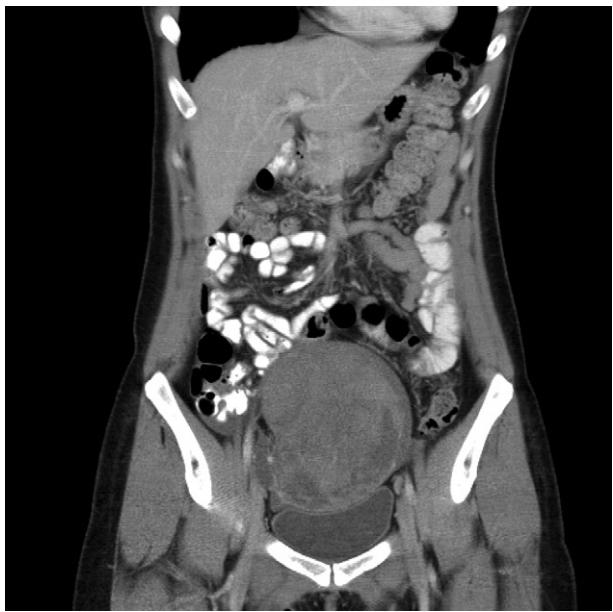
Pelvic computed tomography revealed a round-shaped heterogeneous mass, with a solid and cystic multilobulated pattern, about 8.4 cm × 11.2 cm × 12.7 cm, in the midline anterior pelvis, favoring a left ovarian tumor.
